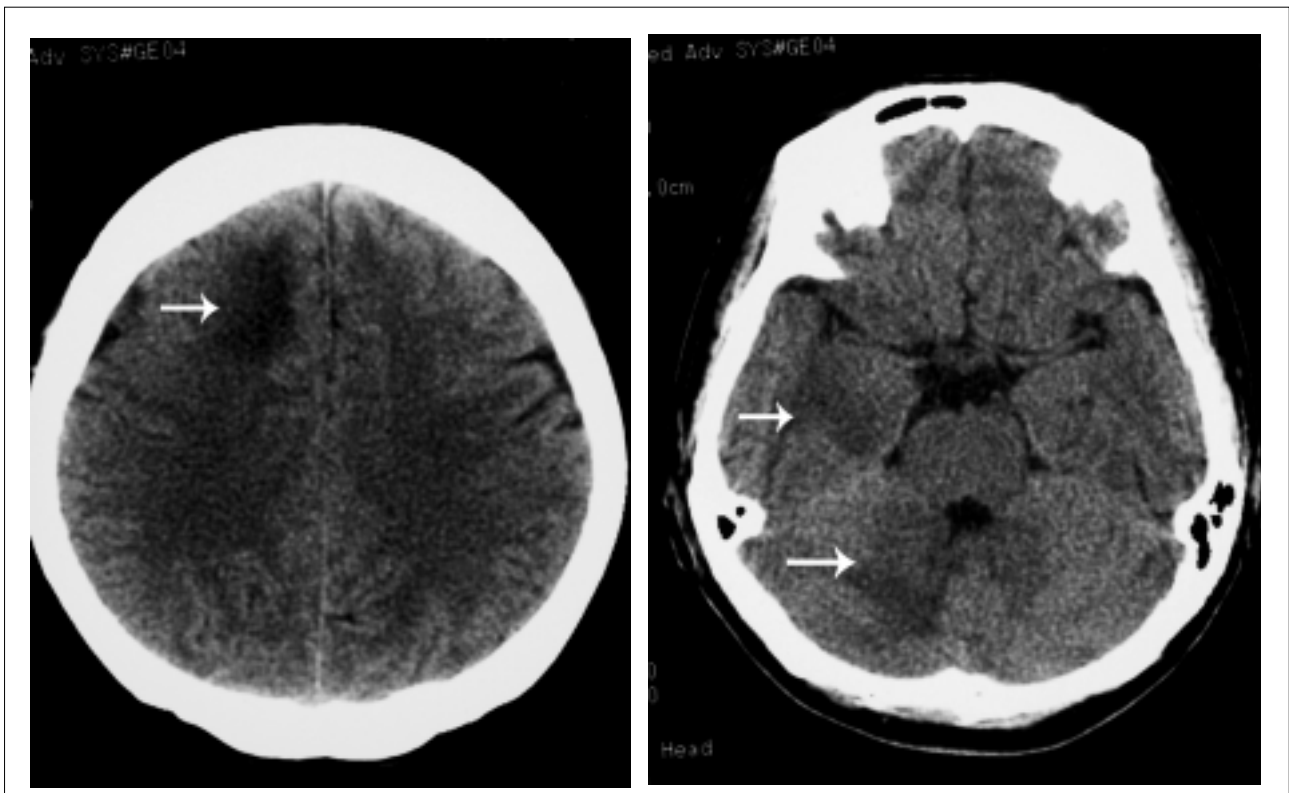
Non-contrast CT brain of Case 3, showing hypodense areas (arrows).
